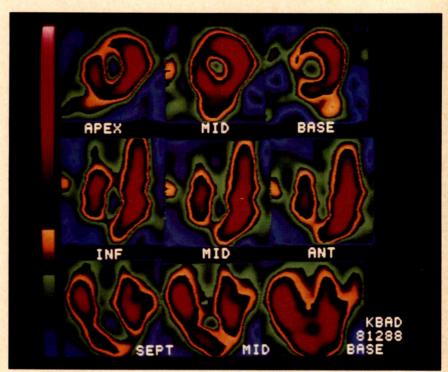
Thallium-201 singlephoton emission computed tomography (SPECT) images during adenosine infusion (top) and at redistribution (bottom) in a patient with left anterior descending stenosis. In each part, three representative slices are shown in the short axis (upper row), horizontal long axis (middle row), and vertical long axis (lower row). A defect (in orange color) involved the anterior (ANT) wall and apex in the adenosine images and filled-in in the redistribution images. INF = inferior; SEPT = septum. (Reprinted with permission from J Am Coll Cardiol.21)
